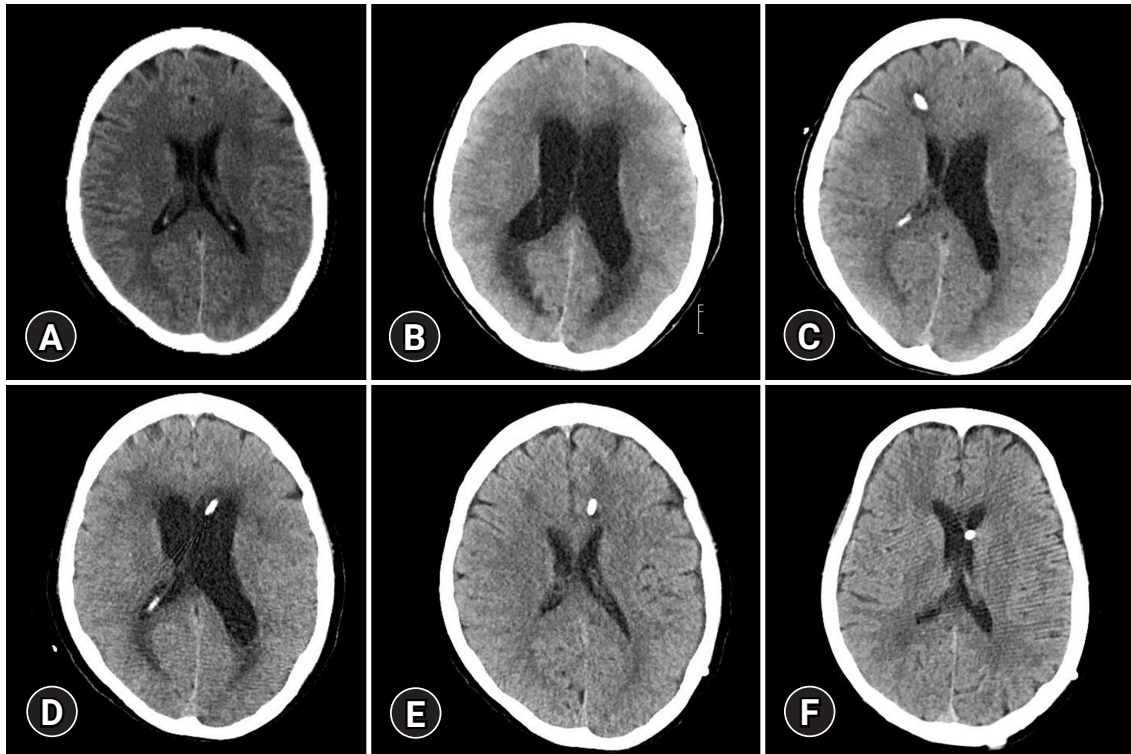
Computed tomography images of the brain. (A) On hospitalization day (HD) 1, without enlarged ventricles; (B) on HD 3, with the enlarged ventricle; (C) on HD 10, with the enlarged left ventricle and emergency external ventricular drainage, inserted at right Kocher's point; (D) on HD 32, with the enlarged ventricle and emergency external ventricular drainage, inserted at left Kocher's point; (E) on HD 45, with a normal ventricle size and ventriculoperitoneal (VP) shunt inserted at left Kocher's point; and (F) 4 months after discharge, with normal-sized ventricles and VP shunt.
